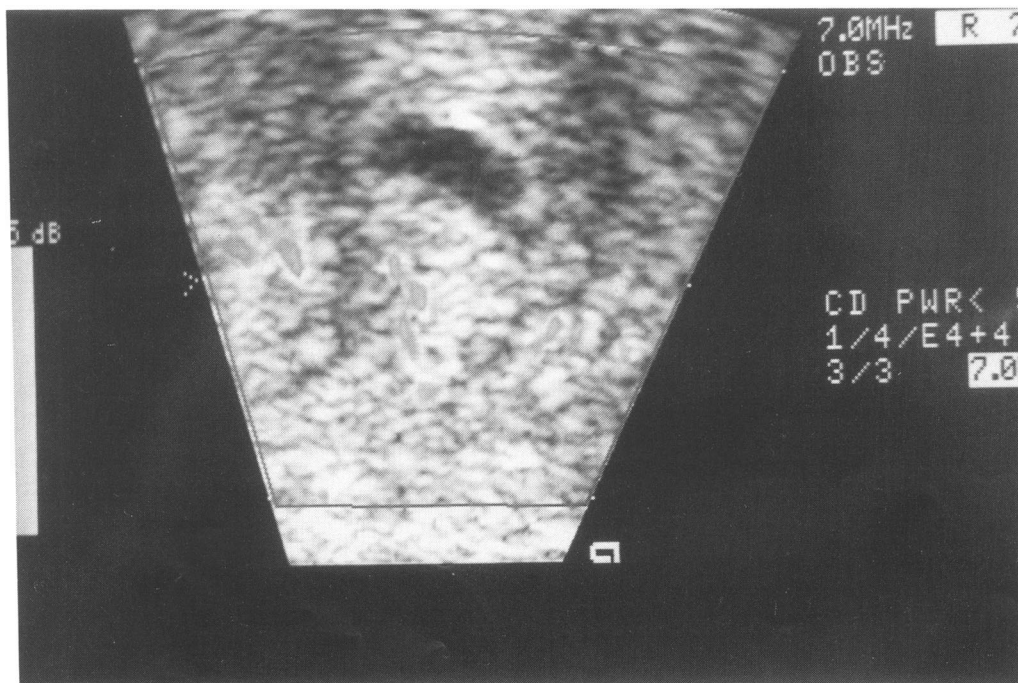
Randomly scattered vessels or intratumoral signals with a characteristic myometrial cyst in adenomyosis was shown by color Doppler energy.
